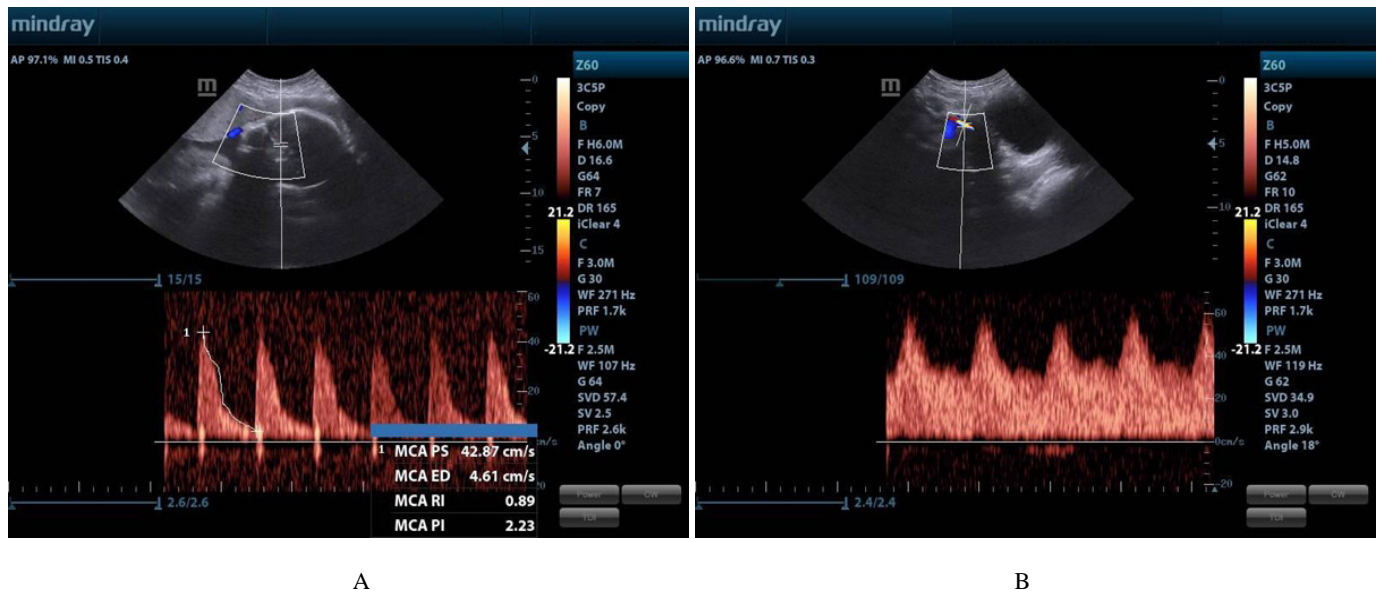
Doppler study of middle cerebral artery (MCA) (A) and umbilical artery (UA) (B) pulsatility index at 40 weeks in a hypertensive patient
